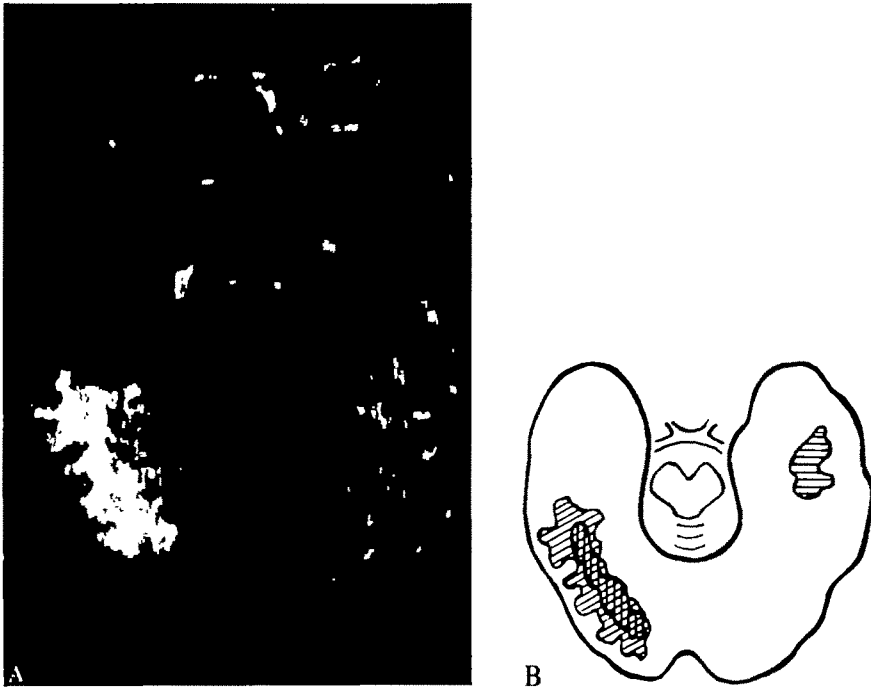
A, axial MRI scan showing an extension lesion in the neocortex and white matter of the right posterior temporal region (*Case 6*). B, tracings of lesions seen on MRI scans showing the axial section of brain parallel to the base of the temporal lobe. Three temporal lobe white matter lesions (2 right and posterior, 1 left and anterior) in the patients with absent recognition memory ERPs are represented by altered orientations of striped lines.
